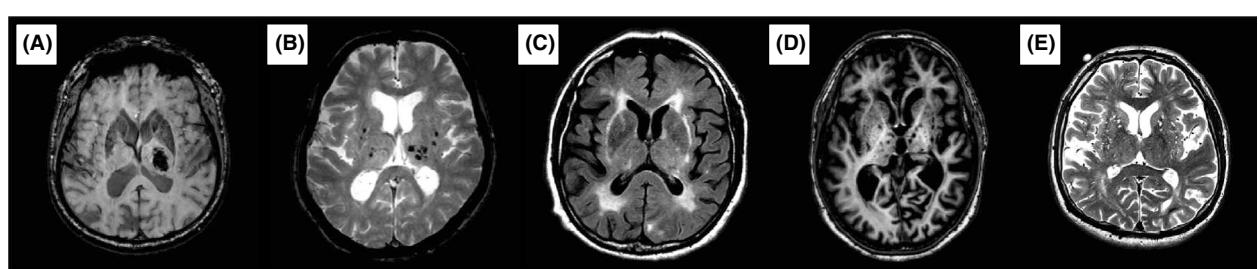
MRI markers of deep perforator arteriopathy. (A) Deep intracerebral haemorrhage. (B) Deep microhaemorrhages. (C) Peribasalganglia white matter hyperintensities (WMH). (D) Deep lacunes. (E) Basalganglia perivascular spaces (PVS). A, B, T2*-weighted gradient recalled echo (T2*-GRE) MRI sequences; C, fluid-attenuated inversion recovery (FLAIR) MRI sequence; D, T1-weighted MRI image; E, T2-weighted MRI image. A, E, 3T MRI; B–D, 1.5T MRI.
